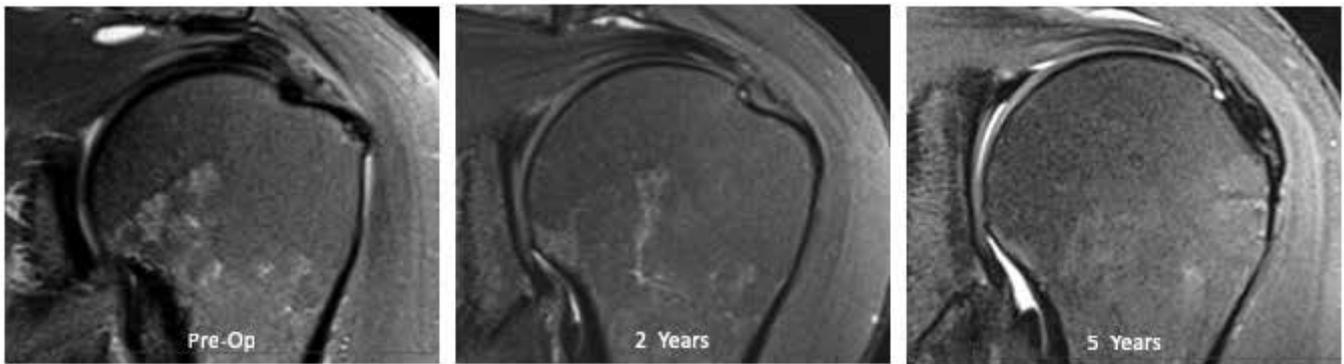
MRI images of an intermediate-grade, bursal-sided tear, which was completely healed at 2 years and remained completely healed at 5 years.
